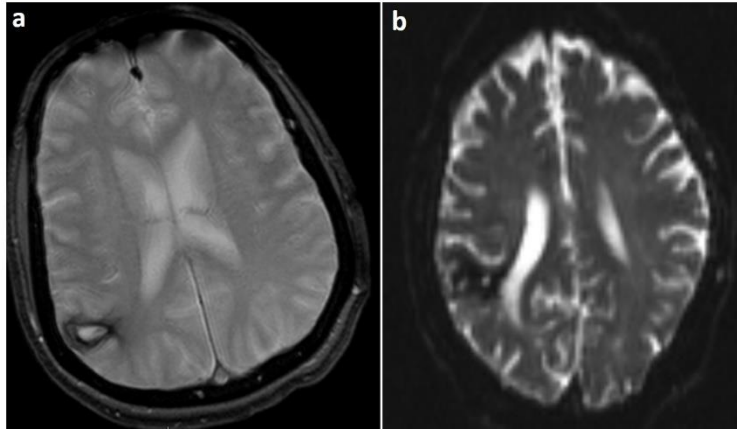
(a&b) (a) T2*WI and (b) DWI-b0 showed hypo intense signal signifying acute Rt. Posterior parietal hematoma.
